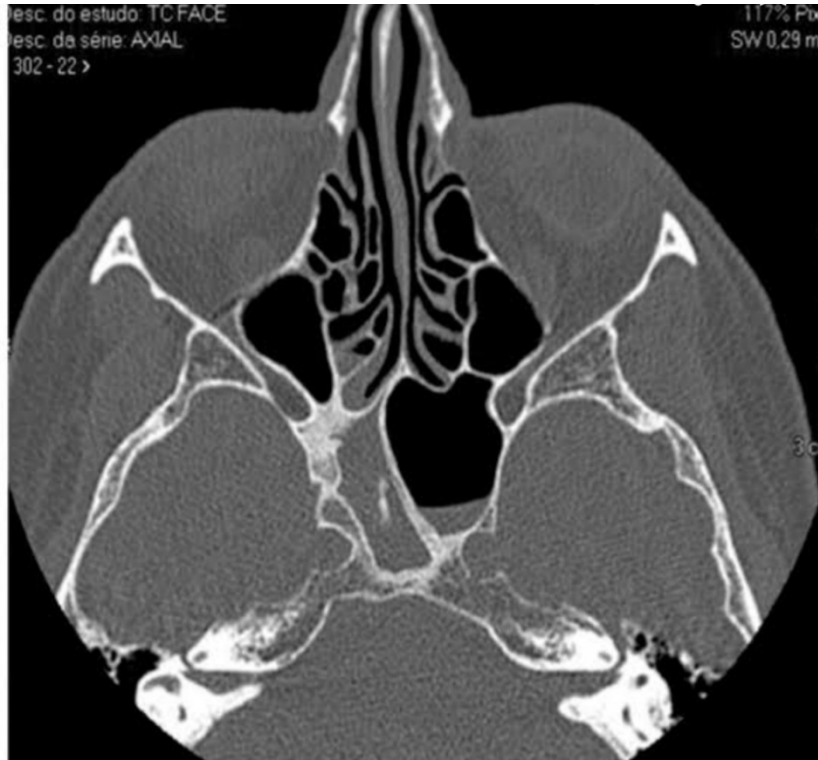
CT Image (axial section) showing posterior ethmoid air cells & sphenoid sinus
